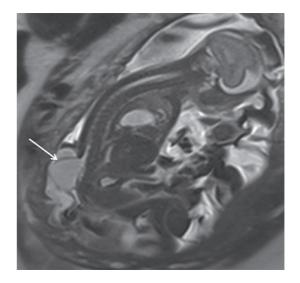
Fetal MRI sagittal scan showing lumbosacral myelome-ningocele (arrow) with tuft of neural tissue entering the CSF-filled cyst.
